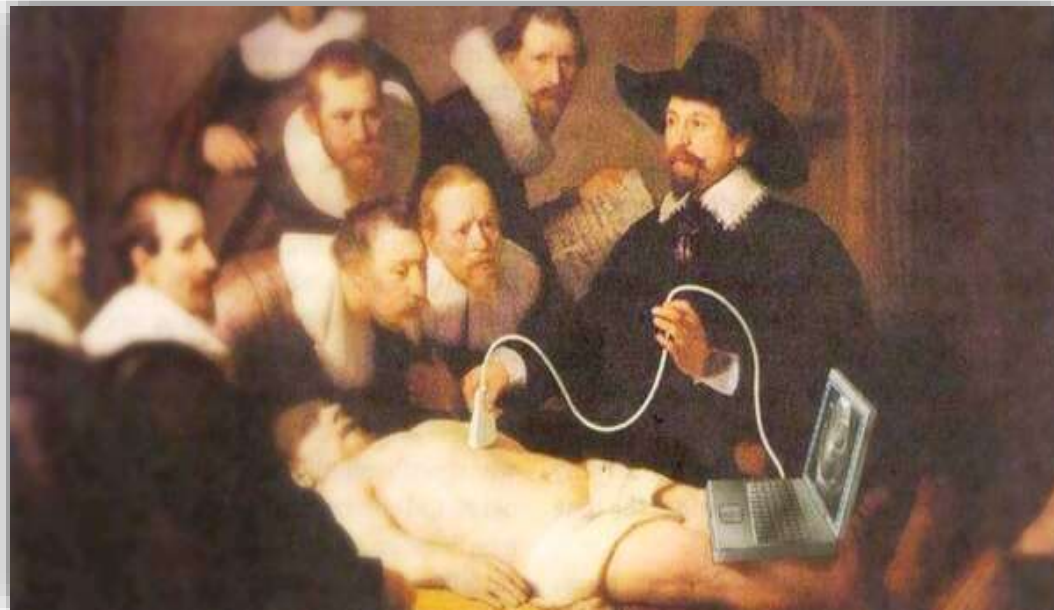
Clinical application of respiratory ultrasonography
